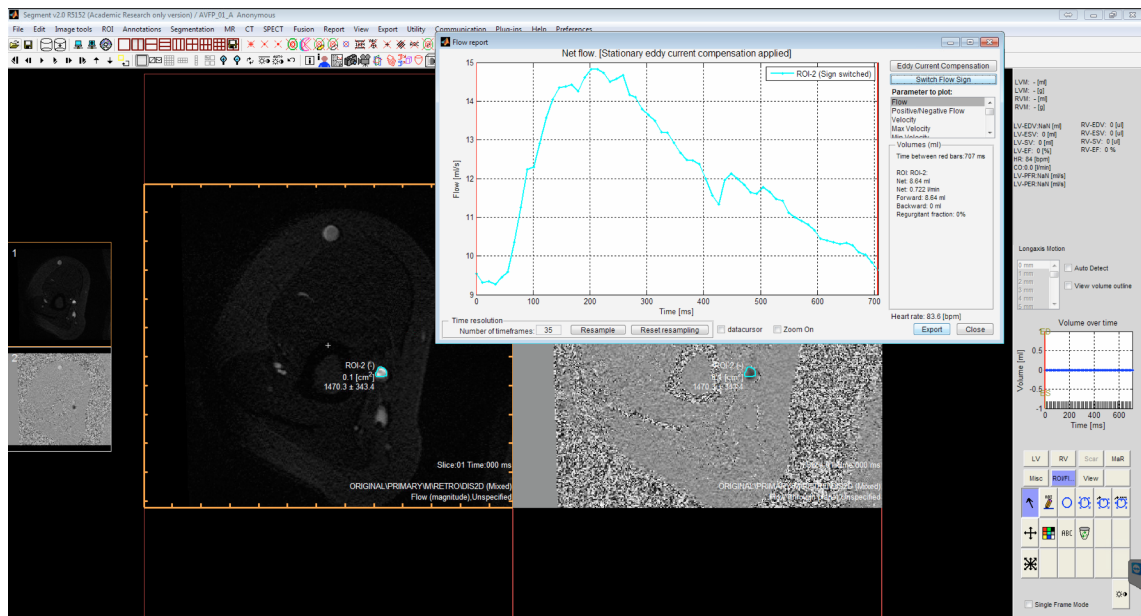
Segment workstation showing contour on a patient's artery, and corresponding velocity waveform from PC-MRI images
